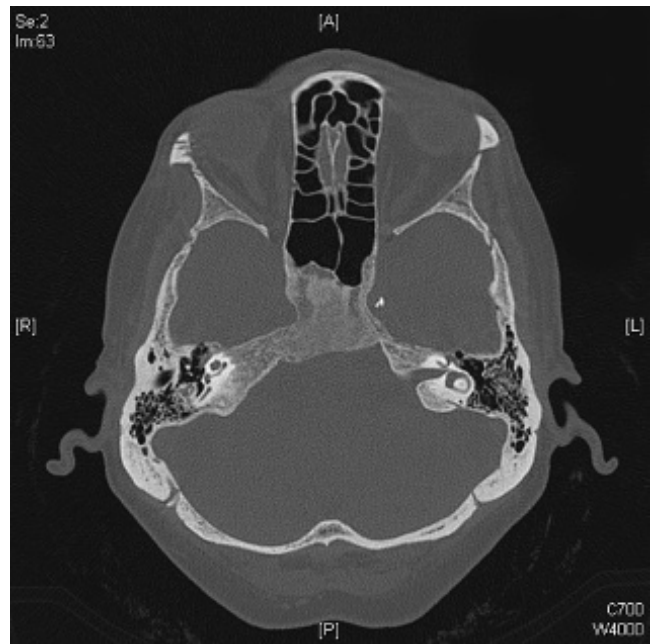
CT Paget's axial.
